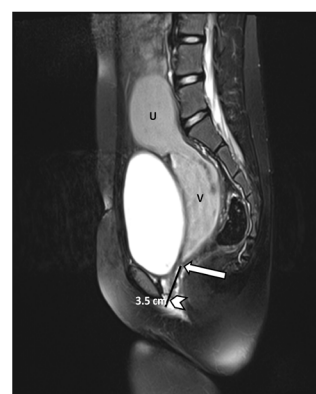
Sagittal T2 fat saturated MRI sequence showing: dilated right uterus "U", dilated right vagina "V", level of obstruction "long arrow" and the distance of the distal vaginal obstruction from the labia minor "arrow head".
